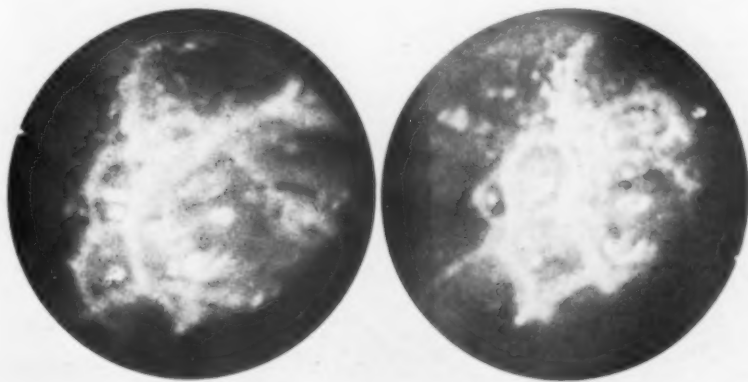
X-ray diagnosis is gastric ulcer. Picture shows only hypertrophied rugae among which a small ulcer can easily be hidden.
